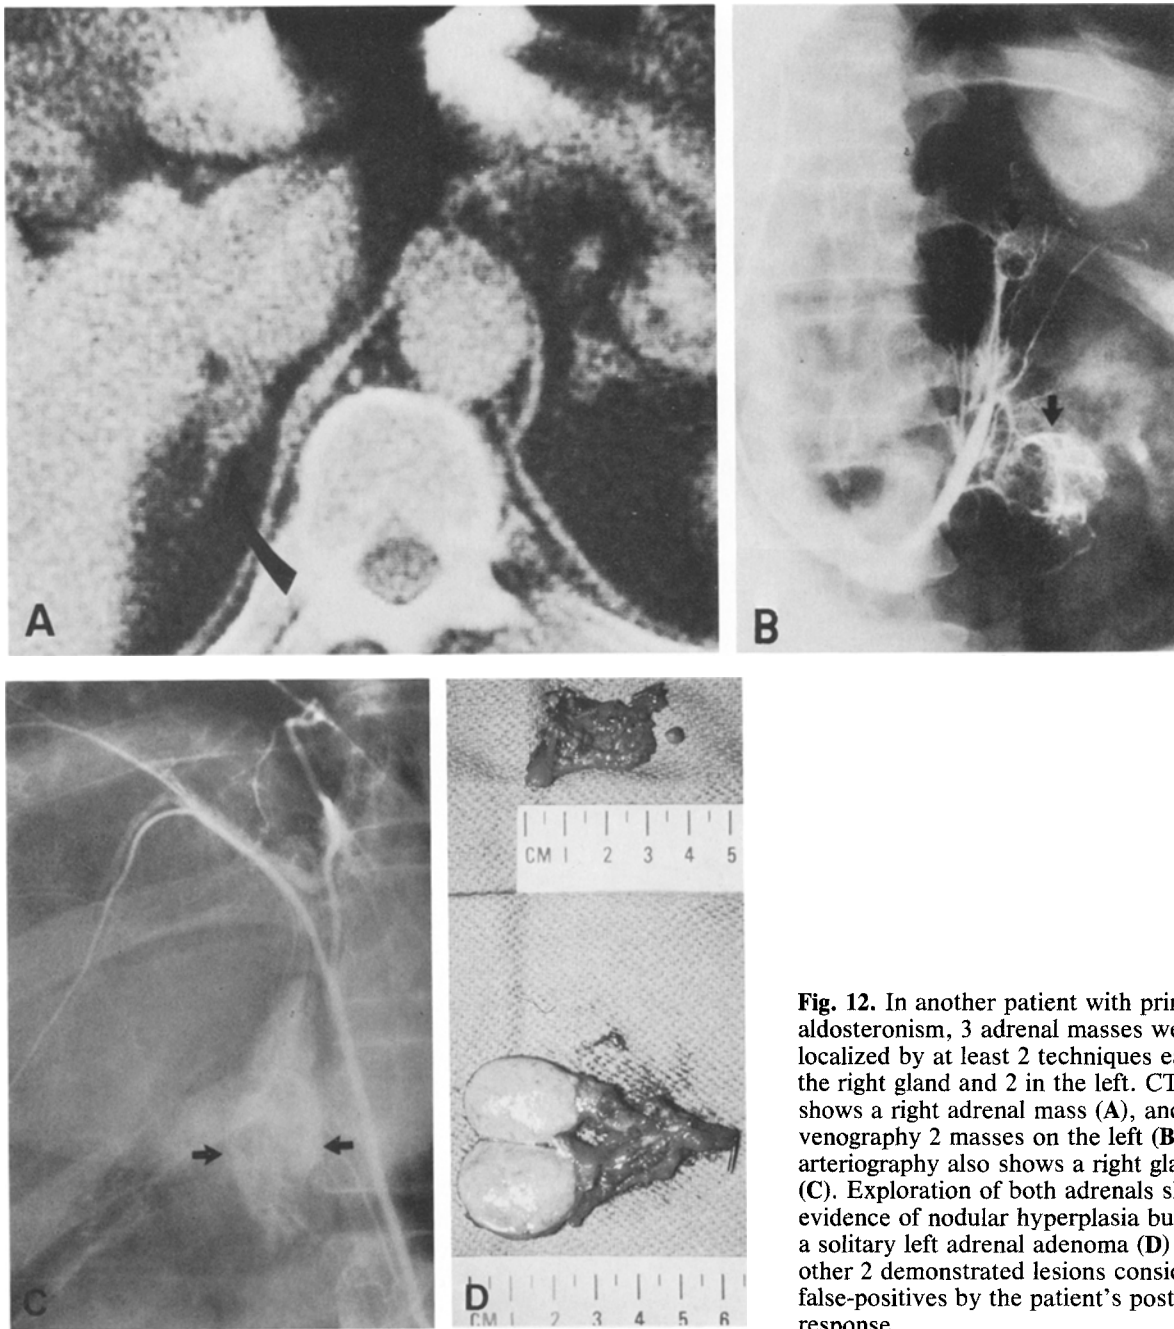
In another patient with primary aldosteronism, 3 adrenal masses were localized by at least 2 techniques each, 1 in the right gland and 2 in the left. CT scan shows a right adrenal mass (A), and venography 2 masses on the left (B); arteriography also shows a right gland mass (C). Exploration of both adrenals shows no evidence of nodular hyperplasia but reveals a solitary left adrenal adenoma (D) with the other 2 demonstrated lesions considered false-positives by the patient's postoperative response.
